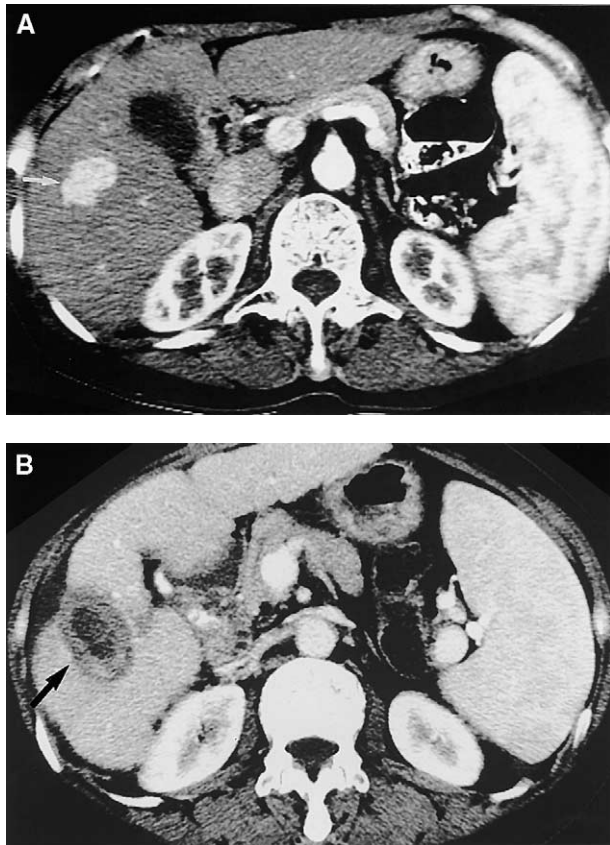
Dynamic contrast-enhanced CT scan of the liver in a 61-old-man (patient 7) with cryptogenic cirrhosis revealed a mass in the right hepatic lobe at the hepatic arterial phase (A) and at the portal venous phase (B) 21 months after cryosurgery for a large mass in segment VIII. There is a necrotic focus in the right hepatic lobe with a thick rim of granulation tissue.
